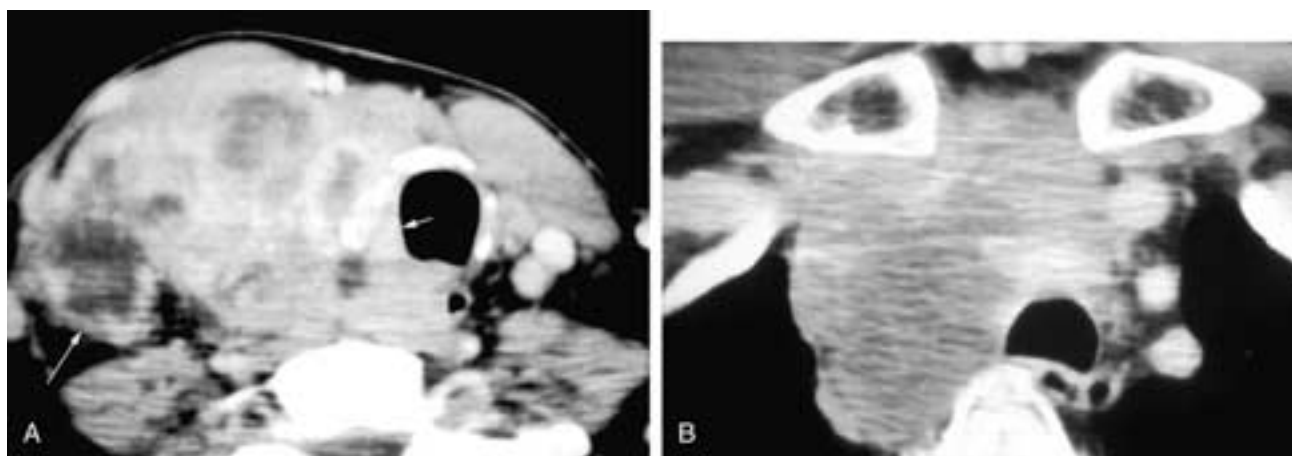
Axial contrast-enhanced CT scan (A) through the lower neck shows a nonhomogeneous thyroid mass replacing the right thyroid lobe. The mass has displaced the trachea to the left and has invaded the lower larynx (*short arrow*). The fat planes around the right thyroid lesion are infiltrated, obliterating the separation from the adjacent muscles and vessels. The right common carotid artery and internal jugular vein are obscured. All of these imaging findings are evidence of the aggressive nature of this anaplastic thyroid carcinoma as it violates the fascial planes. There also is a necrotic right metastatic level III node (*long arrow*). Axial contrast-enhanced CT scan (B) through the lower neck and anterior mediastinum shows an infiltrating thyroid mass that has violated the fascial boundaries, obscuring the adjacent structures. This imaging appearance attests to the aggressive nature of this anaplastic thyroid carcinoma.
